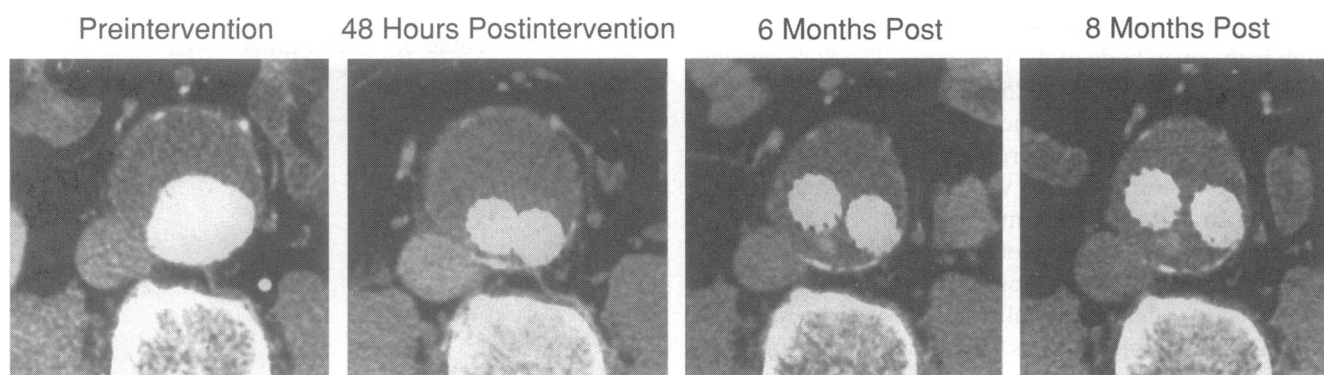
Sequential contrast computed tomography imaging of patient 3 showing the small area of contrast extravasation and the decrease in the size of the aneurysm. Also note the change in position (elevation and separation) of the limbs of the device that occurred with aneurysm shrinkage. This conformational change may be the reason for the appearance of the small leak at the site of prior trauma when no leak was originally seen.
